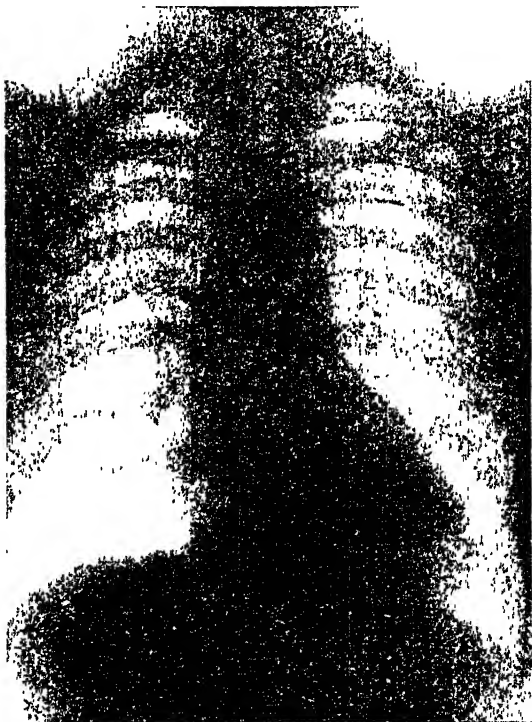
Radiograph of coarctation of aorta, showing abnormal aortic knob, slight enlargement of heart to left, and typical serrations of ribs
